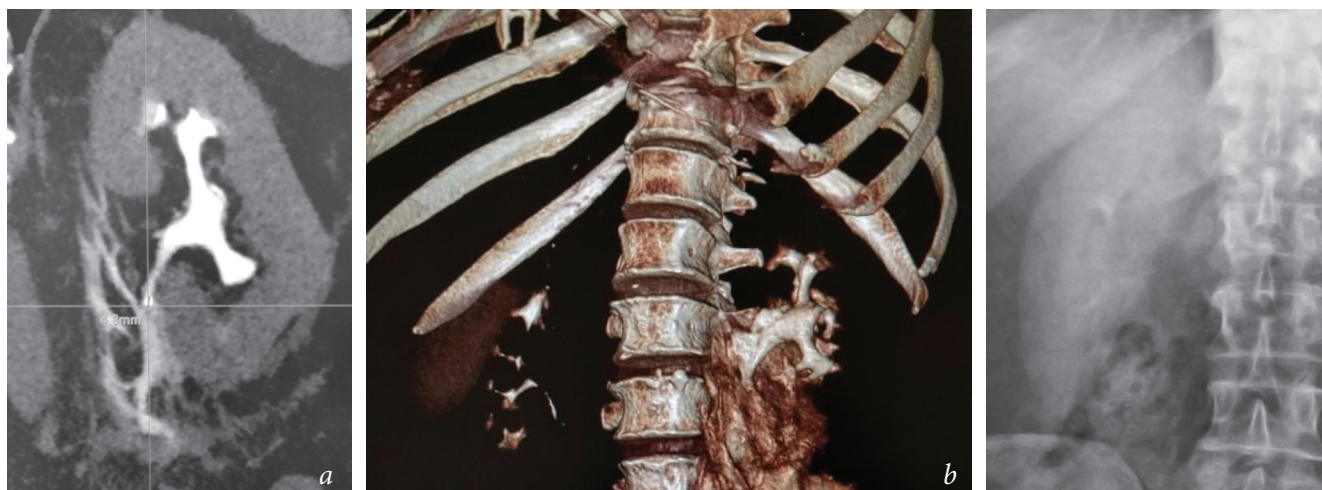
Patient M., 57 y. o: *a* – X-ray of the urinary tract (calculus of the upper third of the left ureter); *b* – multispiral computed tomography (calculus of the upper third of the left ureter, urinoma of the retroperitoneal space on the left)
